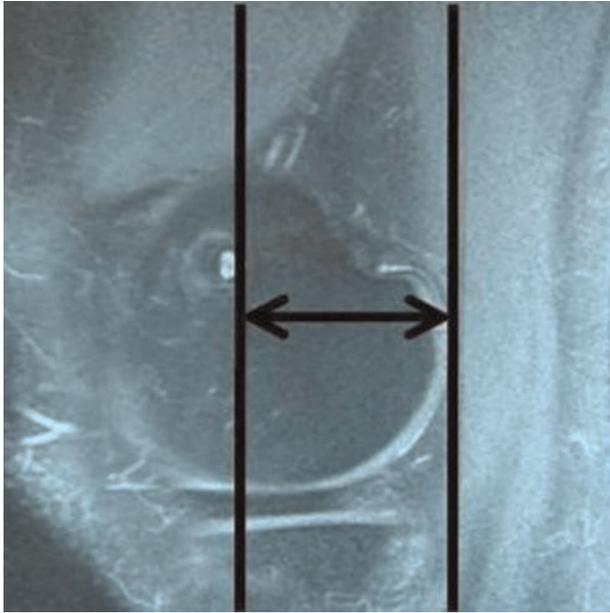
Measurement on MRI with posterior condyle referencing.
